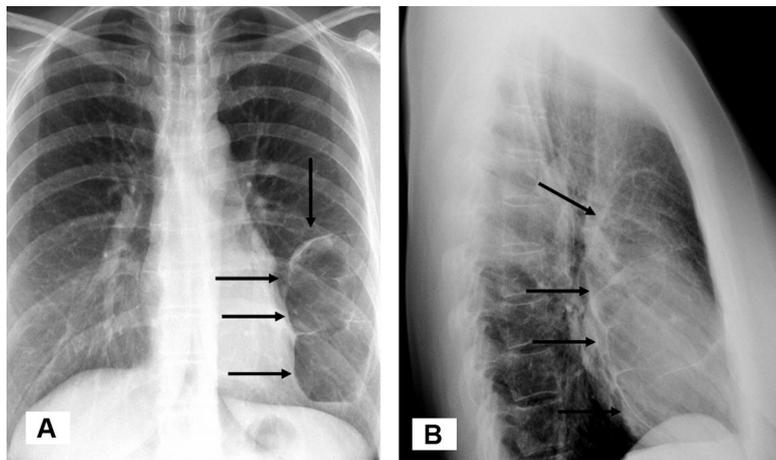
Posteroanterior (A) and lateral (B) x-ray views show a large cystic lesion in the mid-lower field of the left lung, with multiple intralesional septa and well-defined peripheral margins, displacing the lower lobe and the upper part of the upper lobe.
